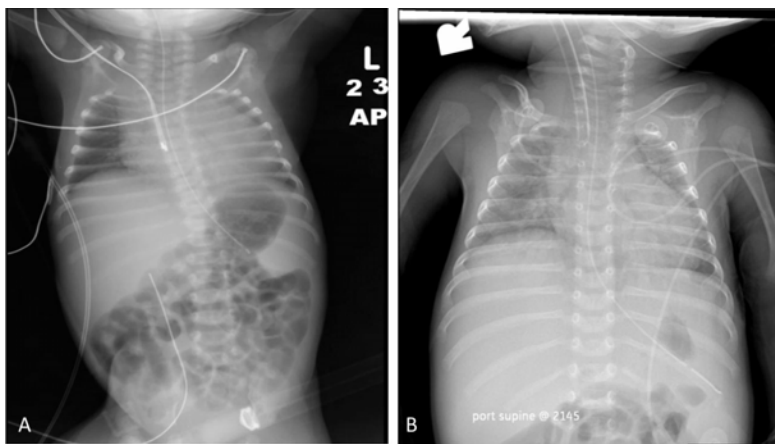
Chest x-ray (A) done at delivery revealing lower-than-expected lung volumes and Chest x-ray (B) done at six weeks of life with progressive pulmonary disease.
